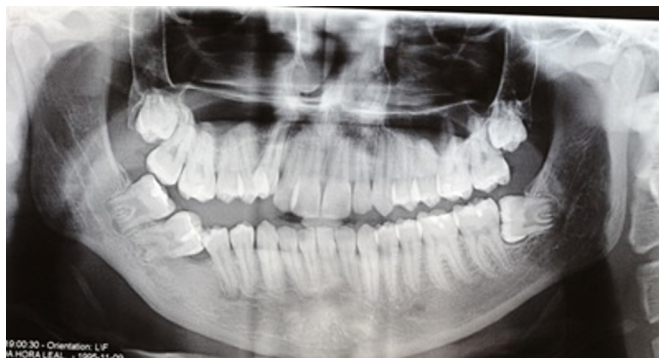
Eight-year radiographic control, showing regression of the lesion with evidence of new bone formation and complete root development of the 45 and 47 dental units.
